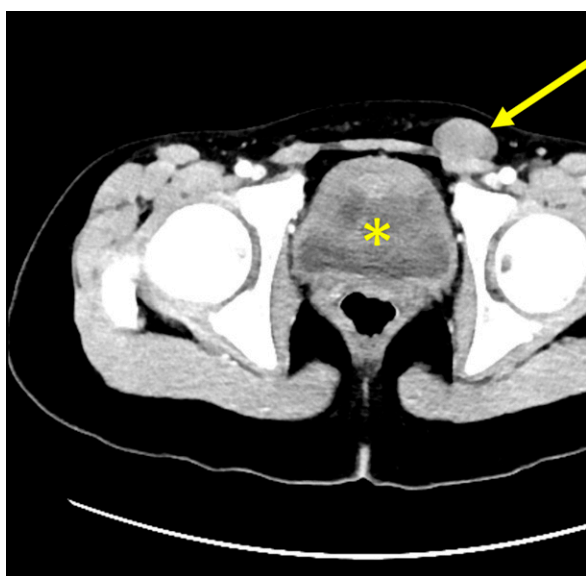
Computed tomographic scan of patient B with absent uterus (asterisk) and gonadal tissue in the left groin (arrow).
